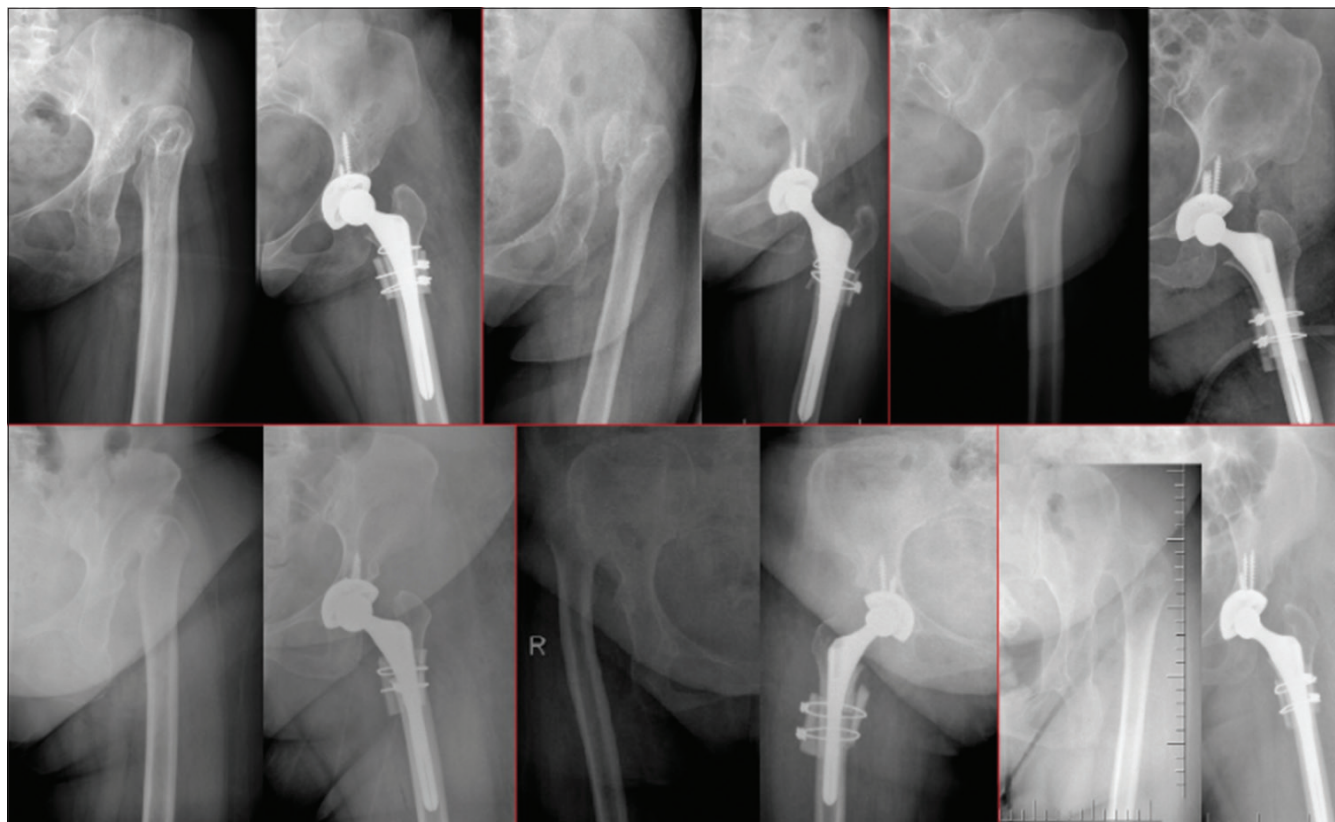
Pre- and postoperative X-rays anteroposterior view of six patients treated with subtrochanteric transverse osteotomy that were fixed by onlay split graft and distal fluted cementless stem showing healed osteotomies in all patients
